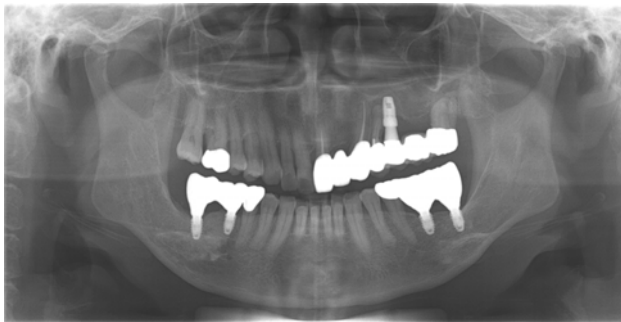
Panoramic radiograph at initial examination.
